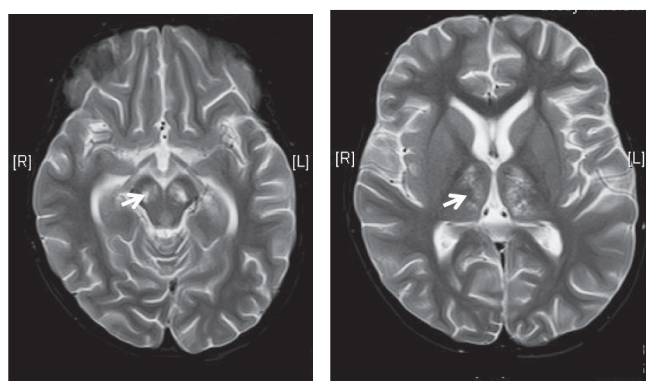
(A & B). MRI in Japanese encephalitis
